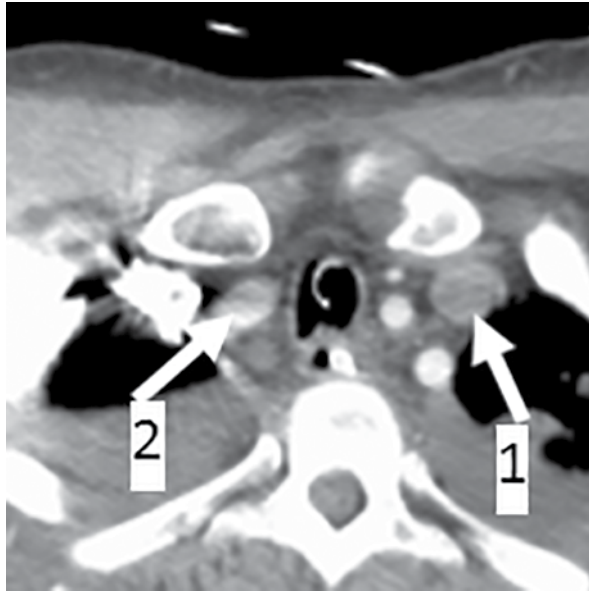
CT scan showing minimal contrast passing through the left internal jugular vein (arrow 1), with normal enhancement of the right internal jugular vein (arrow 2).
